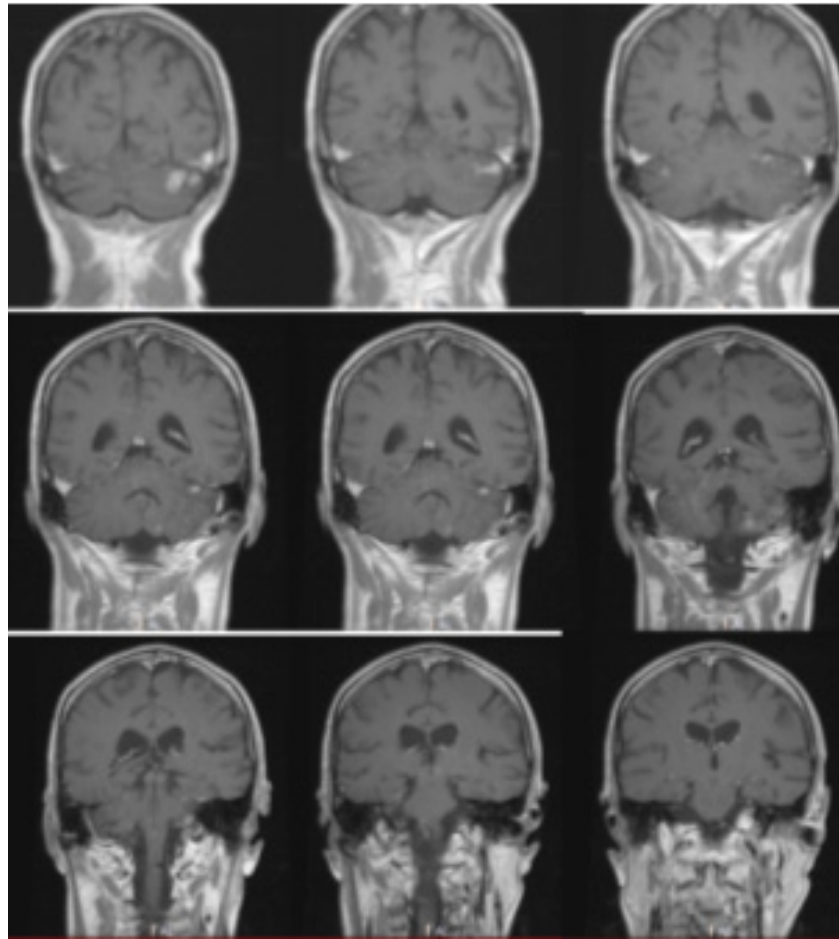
COR T1 FLAIR MRI after 4 months of RT and 3 months of targeted therapy alone.
